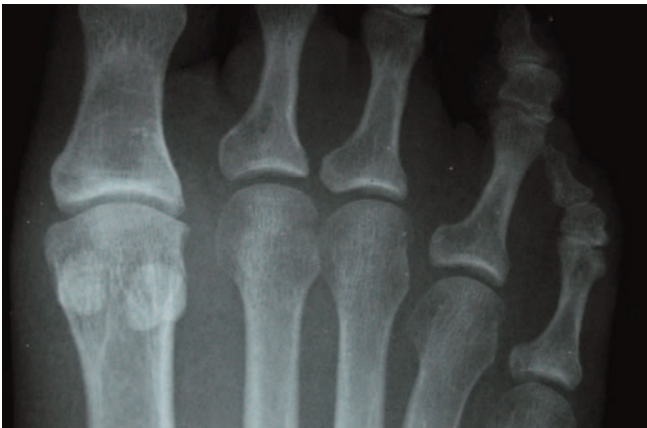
Case Study 3. Postoperative AP radiograph.
